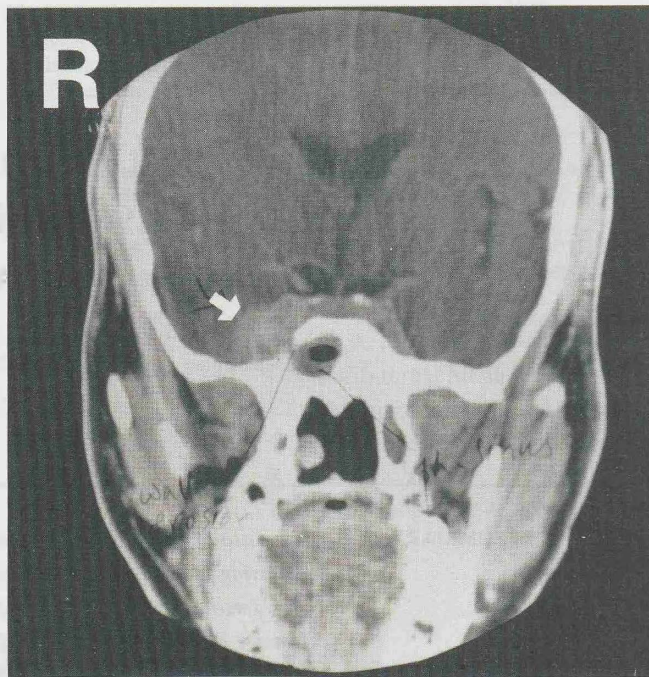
Coronal CT scan demonstrating a mass of invasive aspergillosis which has spread from the right sphenoid sinus to involve the medial side of the right temporal lobe.
